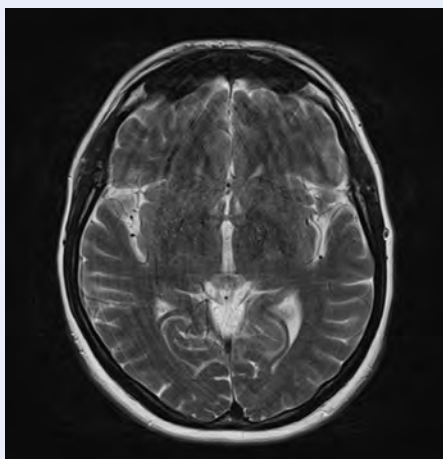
MRI showing stroke of left hemisphere in a day of admission
